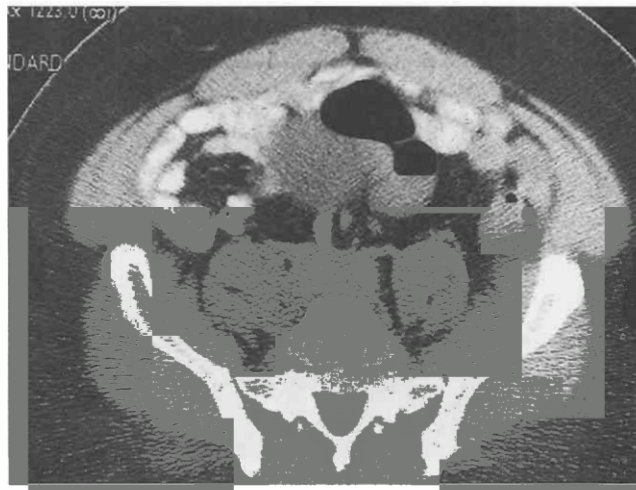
Retroperitoneal fibrosis. Contrast-enhanced CT scan shows a confluent, plaque-like, soft tissue attenuation mass surrounding the proximal common iliac arteries in a 49-year-old patient. The mass was later found to represent retroperitoneal fibrosis.
